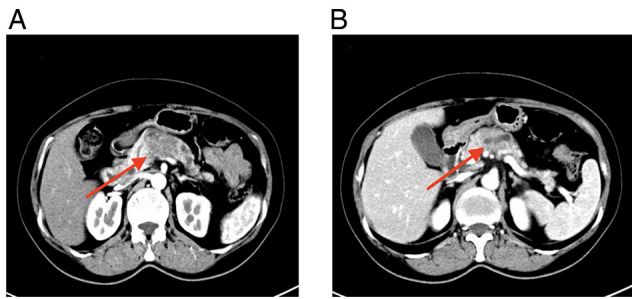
Preoperative contrast-enhanced computed tomography findings of the primary pancreatic lesion. (A) Axial contrast-enhanced CT image showing a hypodense mass-like lesion in the pancreatic body, measuring ~3.1x2.3 cm. The lesion demonstrates lower enhancement than the surrounding pancreatic parenchyma. (B) Axial contrast-enhanced CT image showing atrophy of the distal pancreatic body and tail, accompanied by dilatation of the main pancreatic duct. CT, computed tomography.
